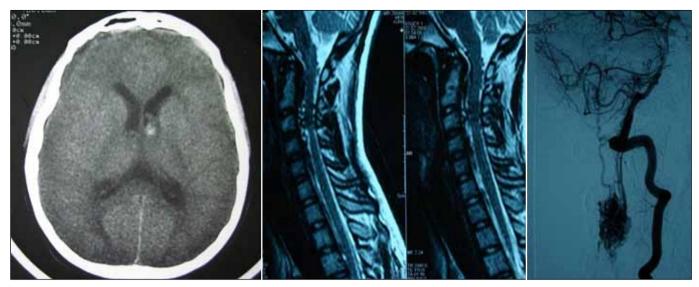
Initial CT scan of a patient revealed intraventricular subarachnoid hemorrhage (above left). Cervical MRI of the same patient revealed a suspicion of a vascular lesion (above middle). An arteriovenous malformation feeding from the vertebral arteries and draining towards the intracranial vessels between C2-C4 levels detected in vertebral injections (above right).
